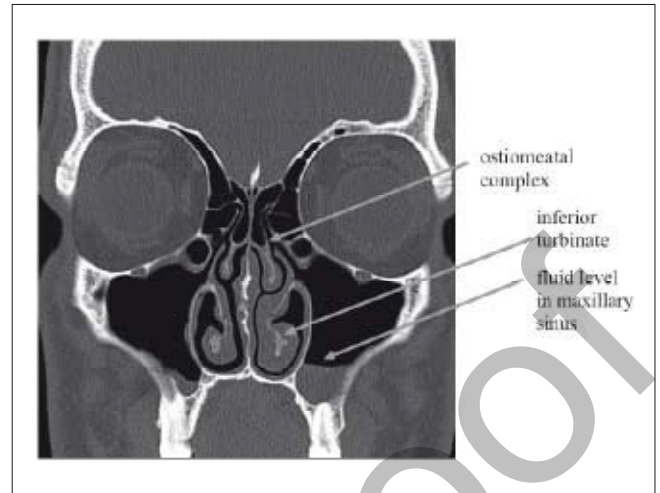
A coronal computed tomographic scan of the nose in patient with acute viral rhinosinusitis. Note the asymmetry of congestion of the nasal turbinates due to the nasal cycle, which also causes congestion in the region of the ostiomeatal complex to block the ostium of the maxillary sinus and restrict clearance of mucus from the sinus. A fluid level is seen in the maxillary sinus. The scan demonstrates the involvement of the sinuses even in an uncomplicated common cold.
